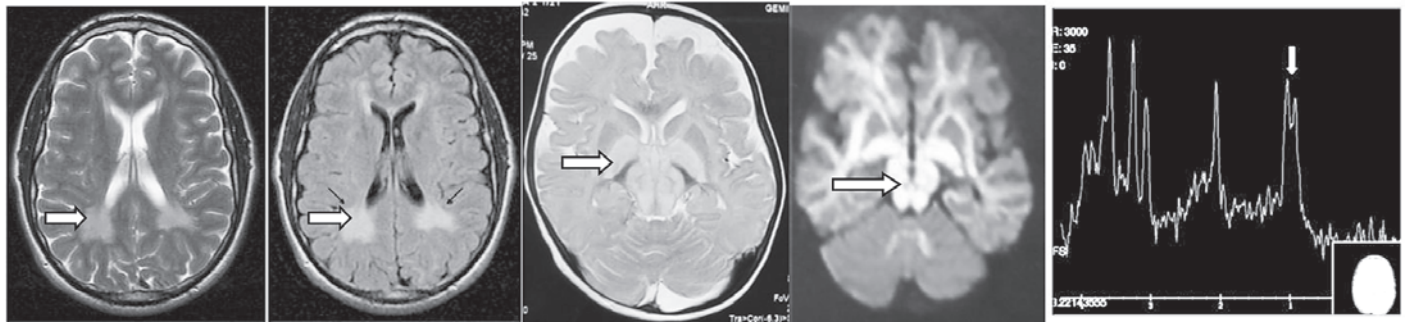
(a & b).Phenyl ketonuria Axial T2 and FLAIR MR image shows periventricular white matter changes predominantly in parieto occipital region
